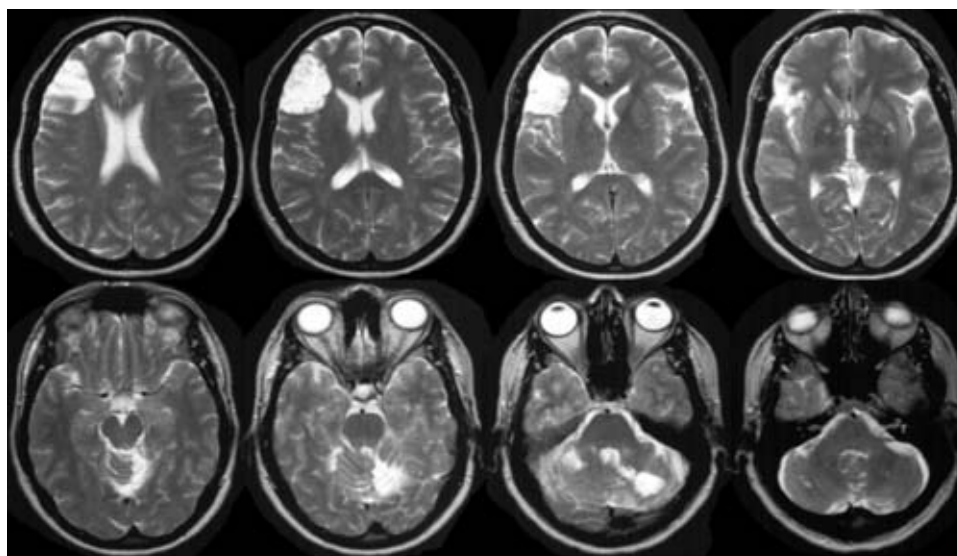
Dangers of cerebral angiography. A young female had a cerebral angiogram performed for complaints of headache. All noninvasive imaging up until that time was normal, with no suspicion of aneurysm, arteriovenous malformations (AVM), vasculitis, or other indication that the cerebral angiogram would yield diagnostic information. The radiologist who performed the study completed angiography of three vessels uneventfully and then used an exchange-length wire to access the right vertebral artery. This resulted in a shower of thrombus being delivered to the entire cerebral vasculature. The follow-up T2-weighted MRI shows extensive encephalomalacic change in several vascular territories, with concordant permanent clinical deficits to the patient.
